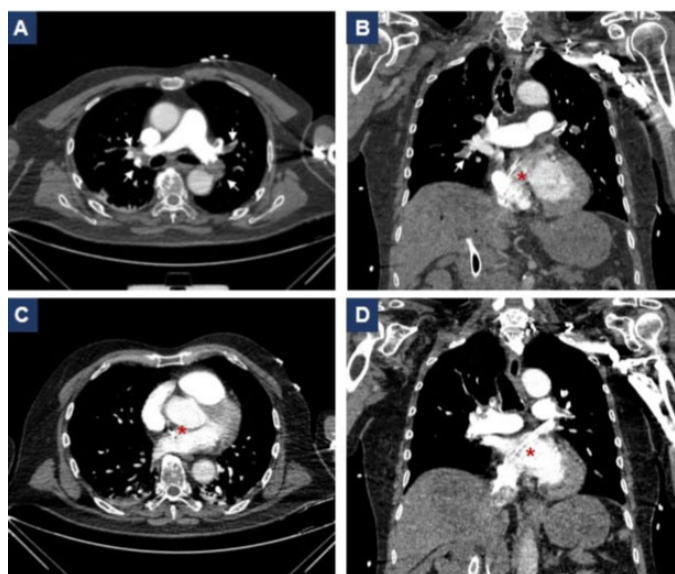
CT chest axial views (A, C) and coronal views (B, D) demonstrating a bilateral central PE (arrows) with a dilated pulmonary artery and showcasing CVC crossing into the right atrium (\*), in the context of high right circulation pressures and PFO.
